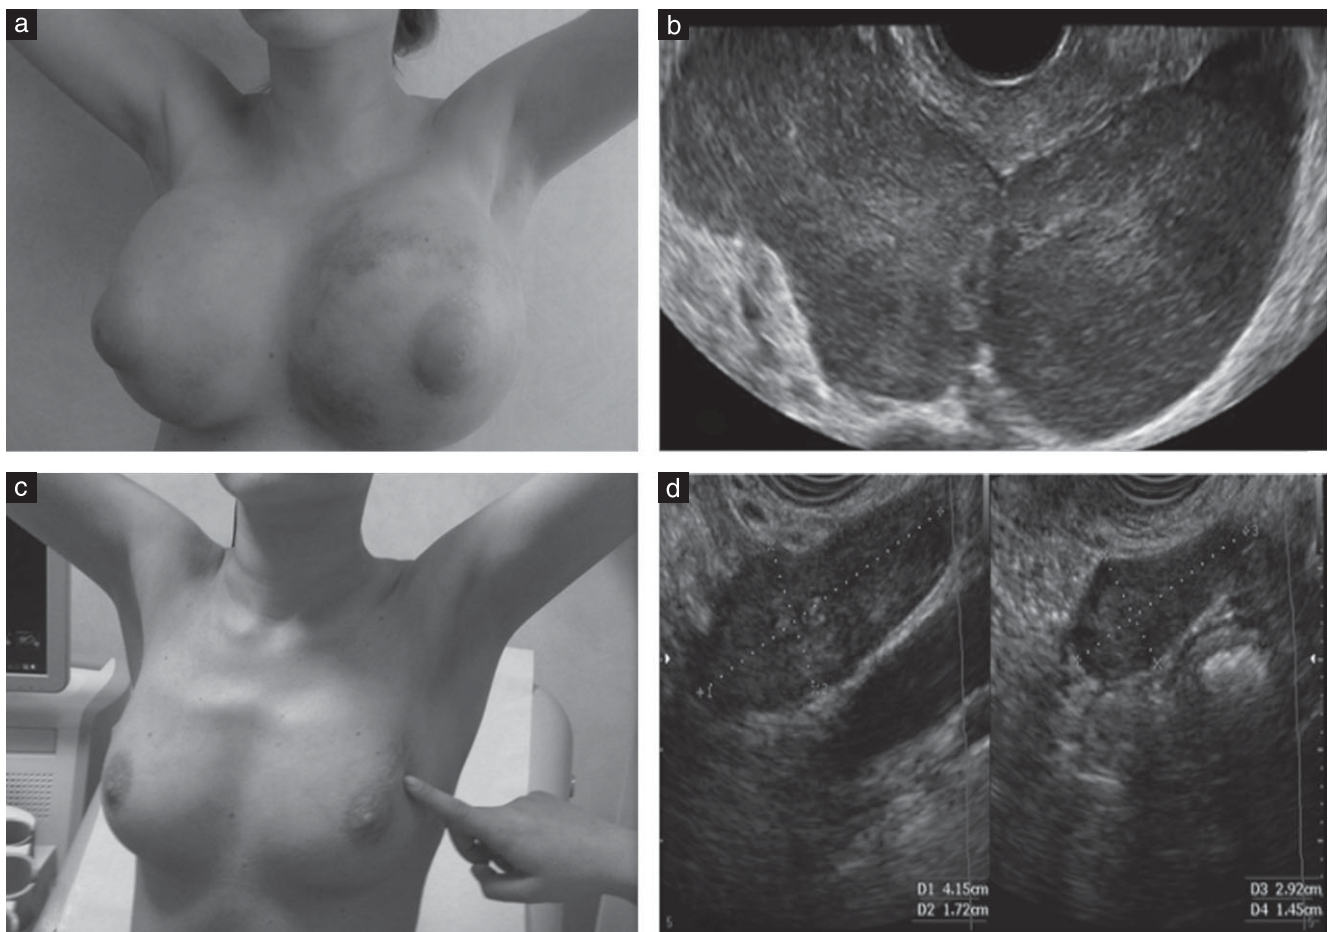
Enlargement of both breasts (a) and ultrasound appearance of the ovarian masses (b) before treatment. Breasts (c) and ovaries (on ultrasound examination) (d) appeared normal after treatment.
